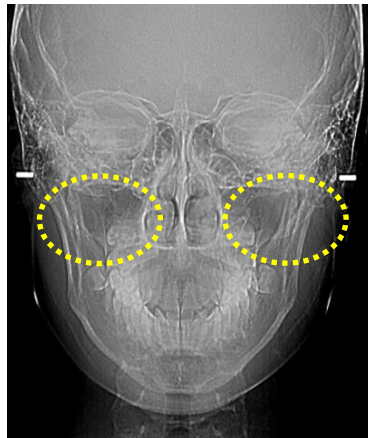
Maxillary right and left sinuses shown on postero-anterior x-ray.
